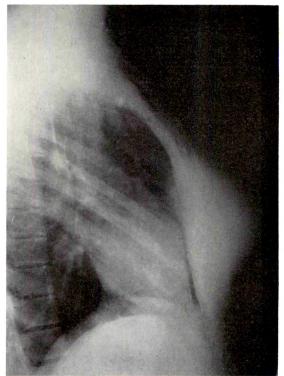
Case II. Lateral chest roentgenogram showing air in the mediastinum as well as in the soft tissue of the chest wall. Note that some air has dissected downward into the preperitoneal structures anterior to the liver.
